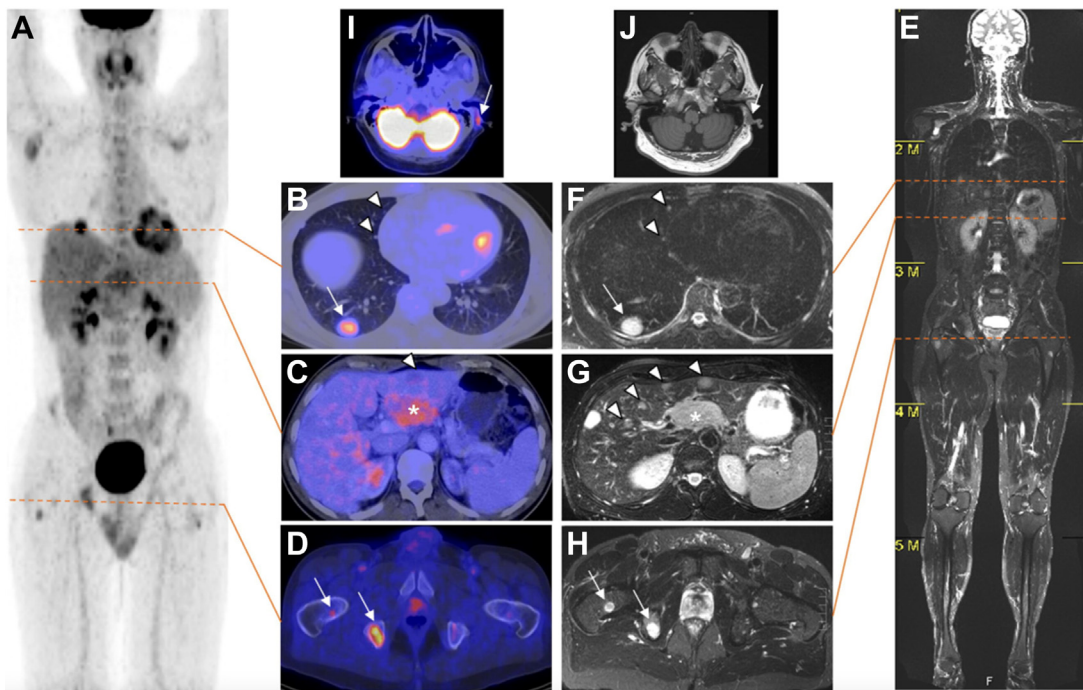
PET/CT (A–D) and whole-body MRI (E–H) of patient with metastatic malignant melanoma. CT and MRI detected more lung metastasis than PET/CT (B and F, arrows), and MRI found more liver lesions than PET/CT (C and G, arrows). Bone metastasis was equally detected (D and H, arrows). Nodal metastasis behind the left ear (I and J, arrows) was detected solely by PET/CT. (From Pfannenbergs C, Aschoff P, Schanz S, Eschmann SM, Plathow C, Eigtler TK, Garbe C, Brechtel K, Vonthein R, Bares R, Claussen CD, Schlemmer HP. Prospective comparison of 18F-fluorodeoxyglucose positron emission tomography/computed tomography and whole-body magnetic resonance imaging in staging of advanced malignant melanoma. *Eur J Cancer*. 2007 Feb;43(3):557-64; with permission.)
